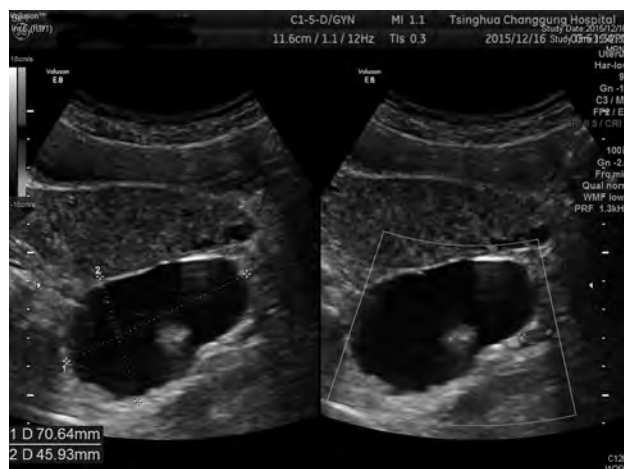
Transvaginal ultrasound examination reveals a cyst measuring 70×46×53 mm with diffuse internal echoes, including a 25×17 mm hyperechogenic component without significant vascularity in the pouch of Douglas.
